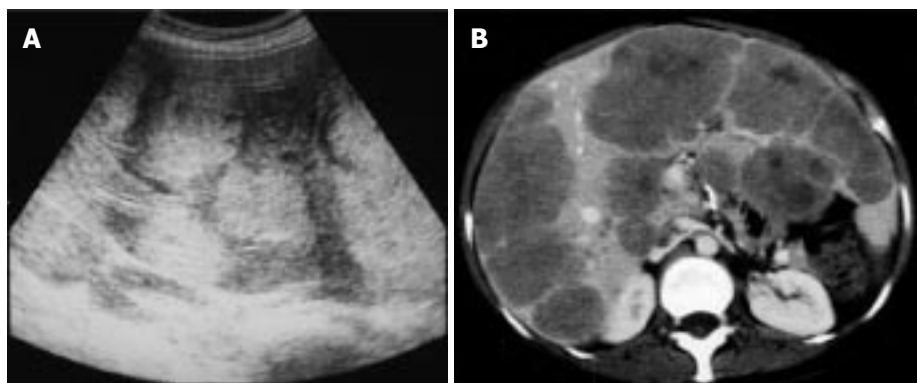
A: Ultrasonography showed multiple hyperechoic masses in the liver; B: Dynamic computed tomography showed multiple liver tumors. The surfaces of these tumors showed mild enhancement.
